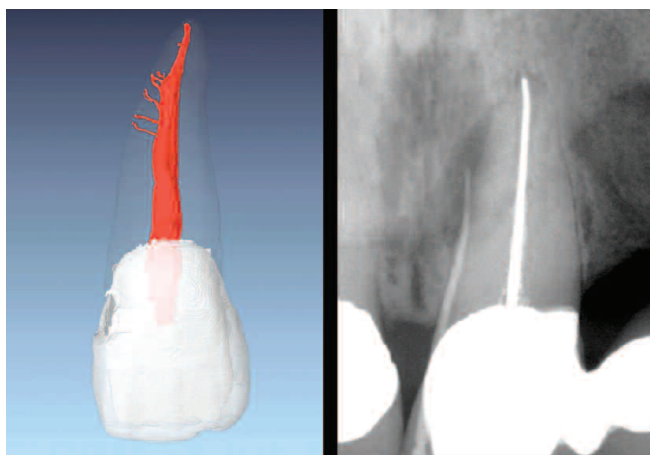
This μ CT image shows a maxillary central incisor root canal system (Courtesy of Dr. Frank Paqué; Zurich, Switzerland). My pre-op film reveals an endodontically failing anterior bridge abutment. Note a gutta percha point tracing a sinus tract to a laterally-positioned LEO.
